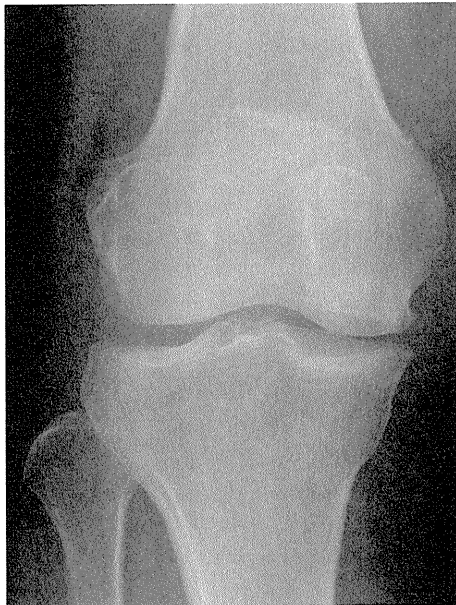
A. An AP radiograph from a 74-year-old woman, who had had sudden onset of right knee pain 7 weeks previously, showing a radio-lucent oval lesion in the medial femoral condyle. The patient was classified as being at stage 2 of SONK and Kellgren-Lawrence grade 3.
